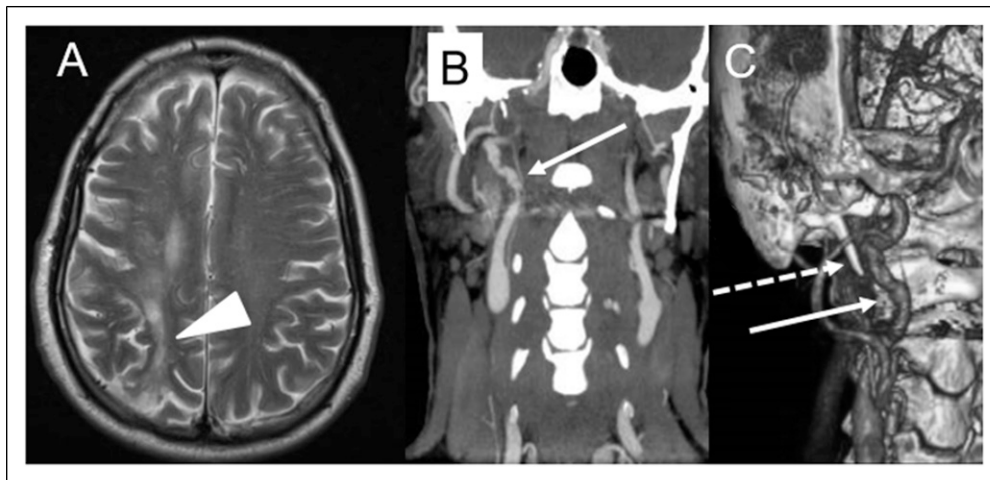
Case no. 1. (A) T2-weighted images 4/2013: right posterior hemispheric juxta-cortical gliosis (arrowhead), interpreted as cortico-basal degeneration. (B) 7/2013 cervical CT-angiography with multiple stenoses and dilatations of the right internal carotid artery (arrow), compatible with chronic or recurrent arterial dissection. (C) Impingement of the styloid process (dotted arrow) on the internal carotid artery (arrow).
